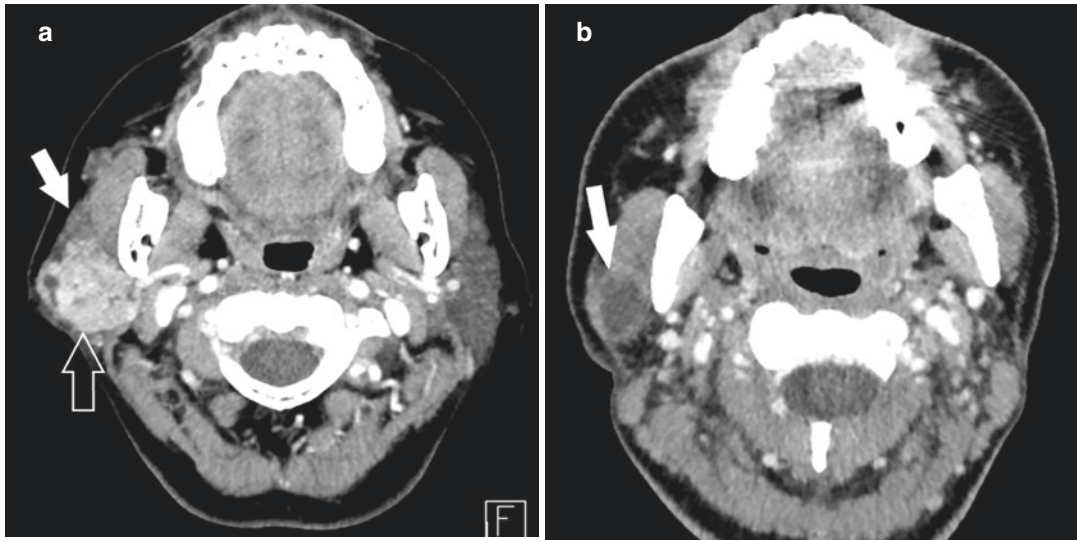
Malignant parotid tumors in two different patients. (a) Mucoepidermoid carcinoma of the right parotid gland. Axial contrast-enhanced CT image shows a lobulated mass containing an internal cystic component (open arrow). The parenchyma adjacent to the mass shows normal enhancement (solid arrow). (b) Primary squamous
